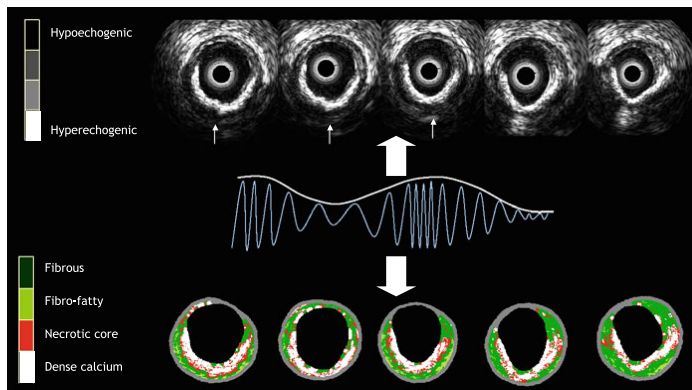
Cross sections of IVUS and corresponding VH-IVUS frames characterizing a calcified plaque. Grey scale IVUS has both a high sensitivity and specificity in the detection of calcium. Calcium usually obstructs the penetration of ultrasound and consequently obscures the imaging of the underlying vascular wall; this phenomenon is known as acoustic shadowing (*thin white arrows* in the top panel). The
